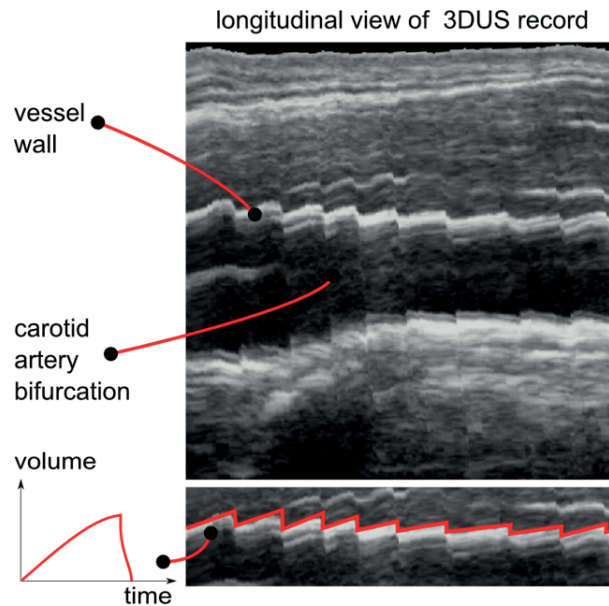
Slice through a transverse 3D-ultrasound scan of the Carotid artery. The red line marks the border between Intima-Media and Adventitia, showing significant vessel expansion and compression. In this case, non-constant velocity of the sweep results in non-periodic steps.
